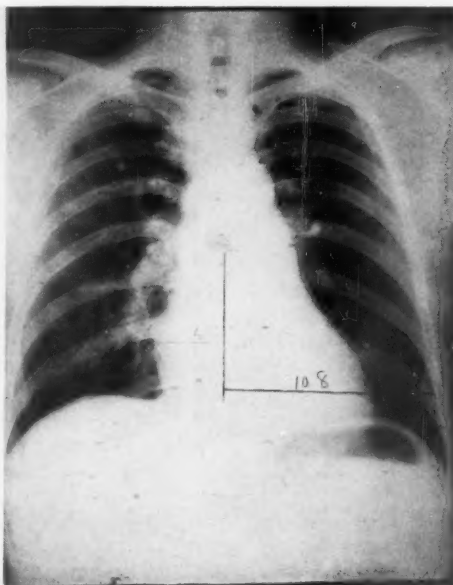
Roentgenogram of the chest, July 14, 1938, showing the decrease in the size of the heart.
